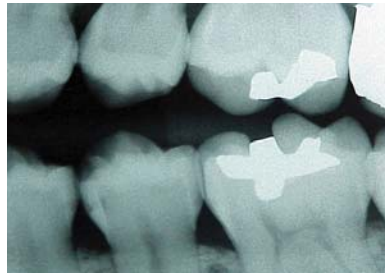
Radiographic evidence of mesial caries in mandibular second premolar.
